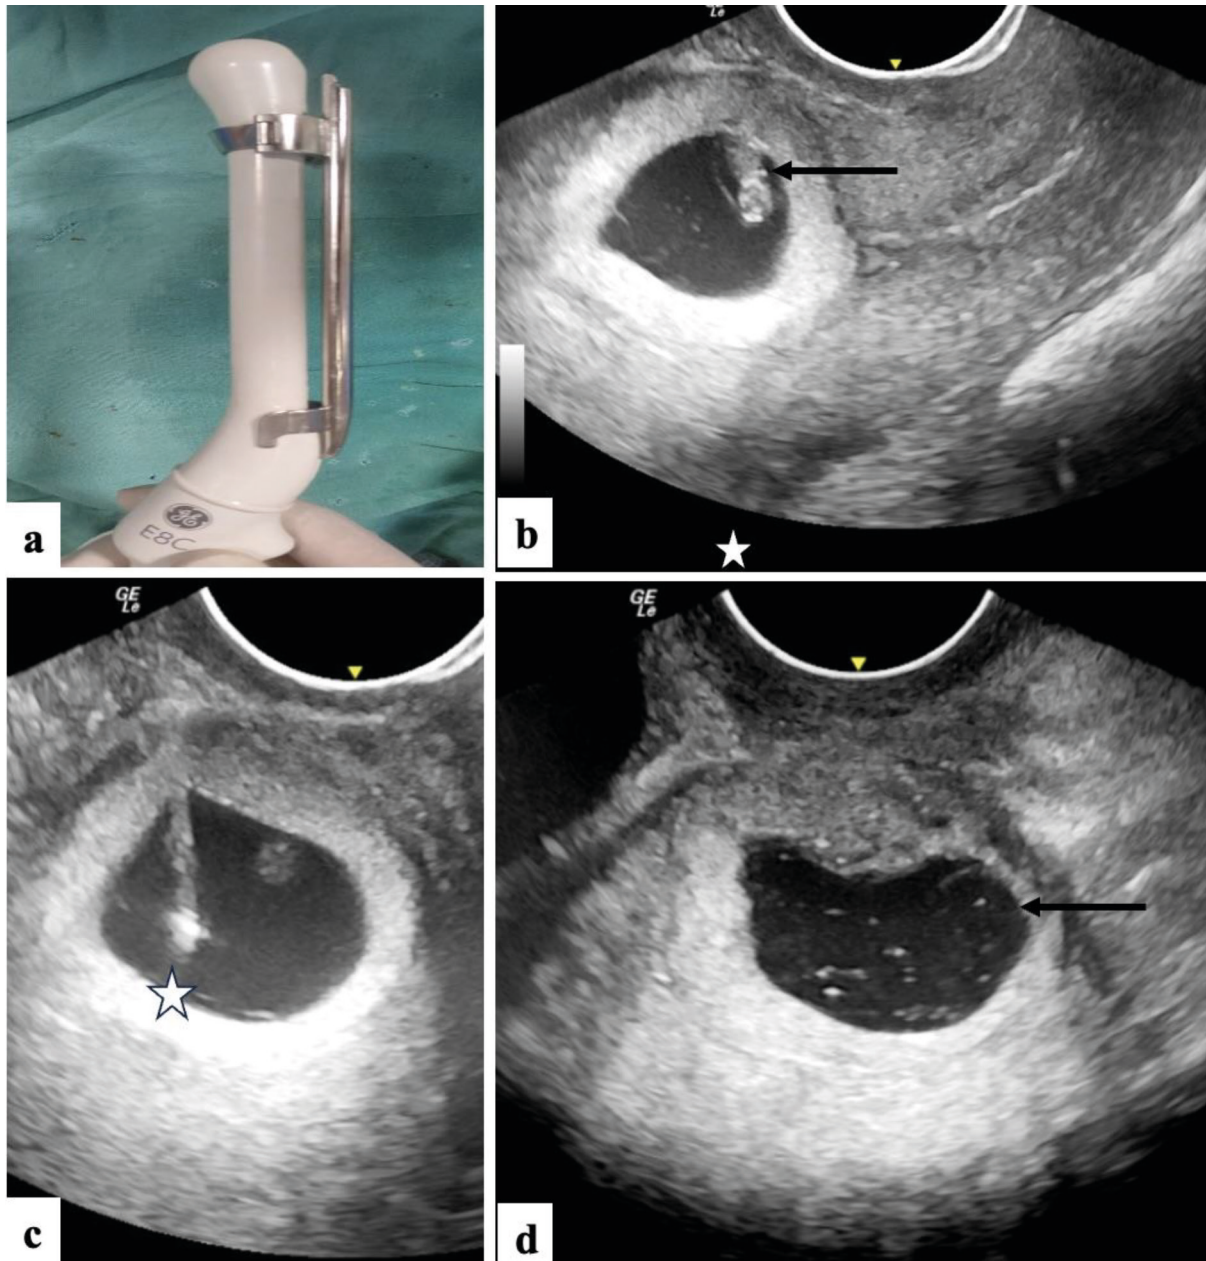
Figure 1a shows a transvaginal sonography (TVS) probe with a straight metallic frame for Chiba needle advancement. On TVS, there was an intrauterine gestational sac with a fetal pole (the black arrow) within it (Figure 1b). Under TVS guidance, the needle tip (shown as the star) was advanced into the gestational sac for the delivery of an intrasac injection of Methotrexate (50 mg) and intracardiac potassium chloride (2 ml of 15%). A 24-hour follow-up TVS shows an absence of fetal parts in the endometrial cavity (the black arrow).
